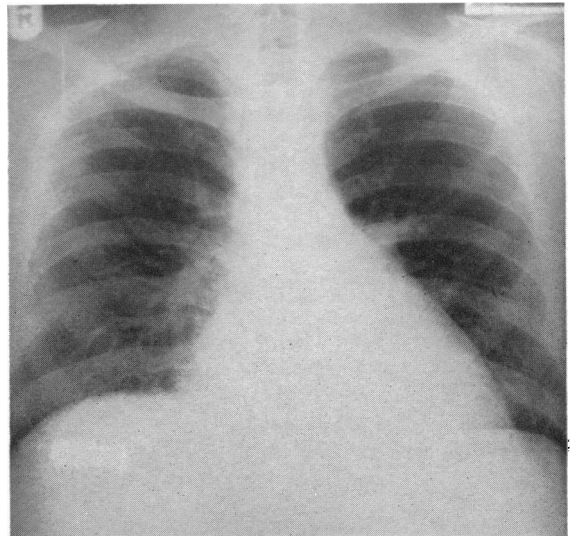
Six-foot postero-anterior radiograph of chest in Case 4, showing generalized cardiac enlargement.
